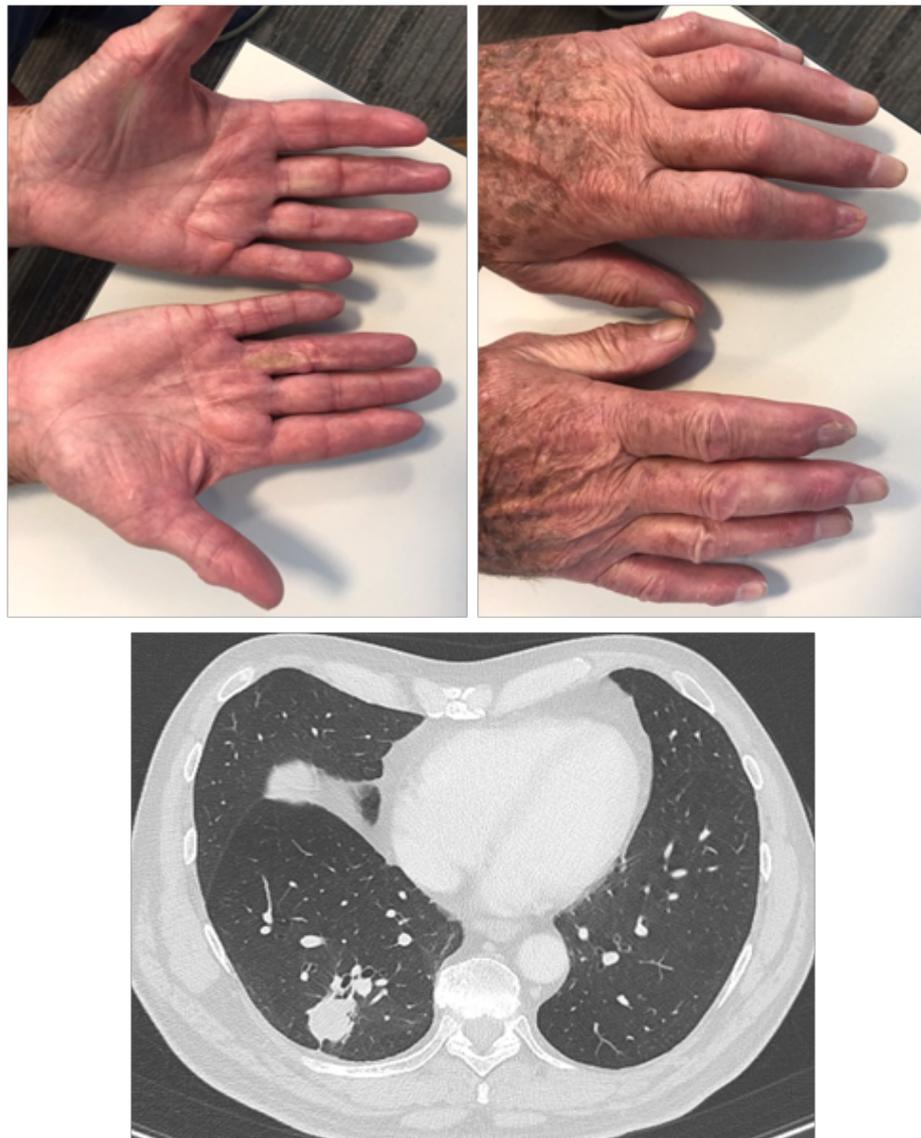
February 2019 (recovery from vasculitis). Most recent CT August 2020 (almost 3 years after immunotherapy):
